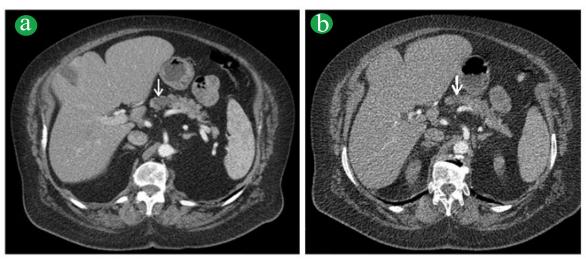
Abdominal CT. (a). Insulinoma on pre-treatment CT (arrow): the pancreatic lesion was 1.5 cm × 1.7 cm large. (b). Insulinoma on post-treatment CT: the pancreatic lesion appeared markedly reduced in size with necrotic behaviour.
